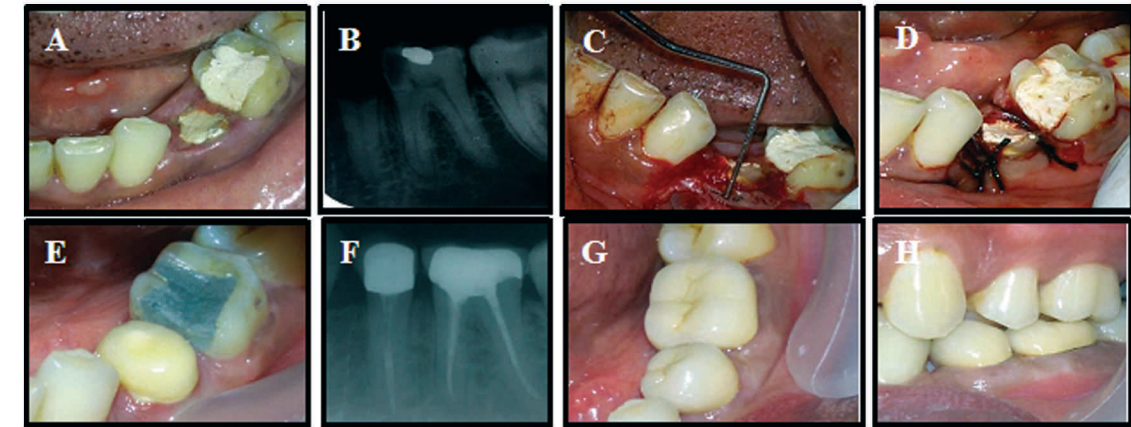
Pre op photograph showing 35 with reduced clinical crown height. B- IOPA of the same region with adequate bone height. C- Osteotomy done to remove 3 mm of bone. D- Flap apically repositioned and sutured. E- Post op photograph showing 35 with 3 mm gain in clinical crown. F- Post op radiograph showing 35 with post and core and crown. G, H- Post op photograph showing rehabilitation with porcelain- fused- to- metal crown.
